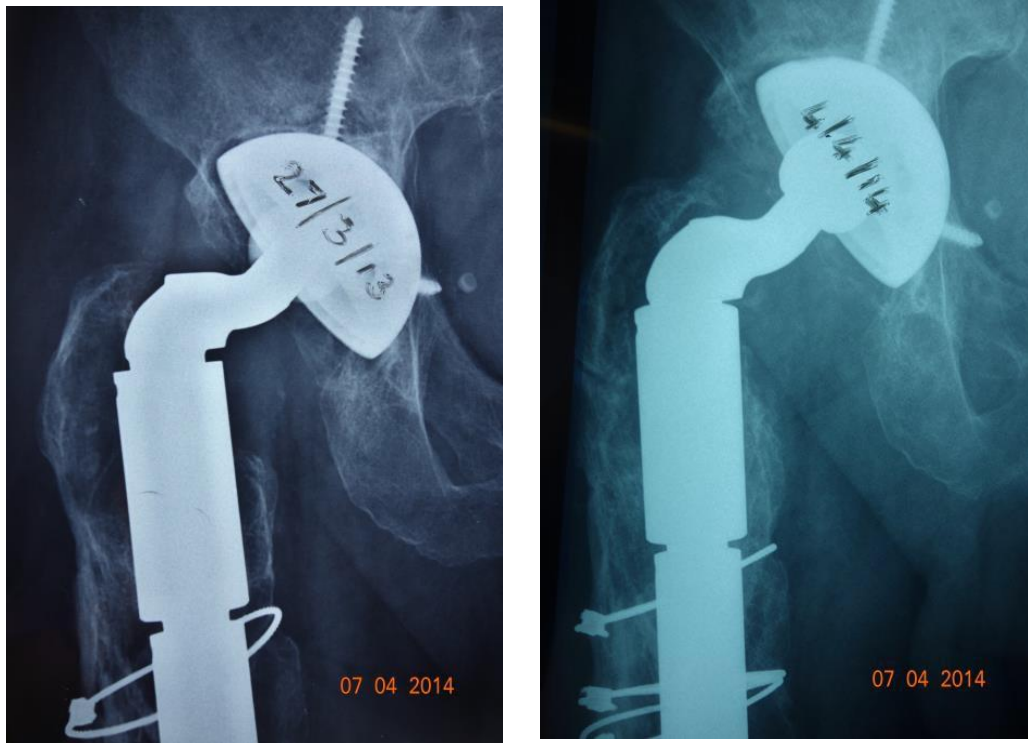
X-ray of the right hip taken at presentation showing a lysis halo around the acetabular cup
